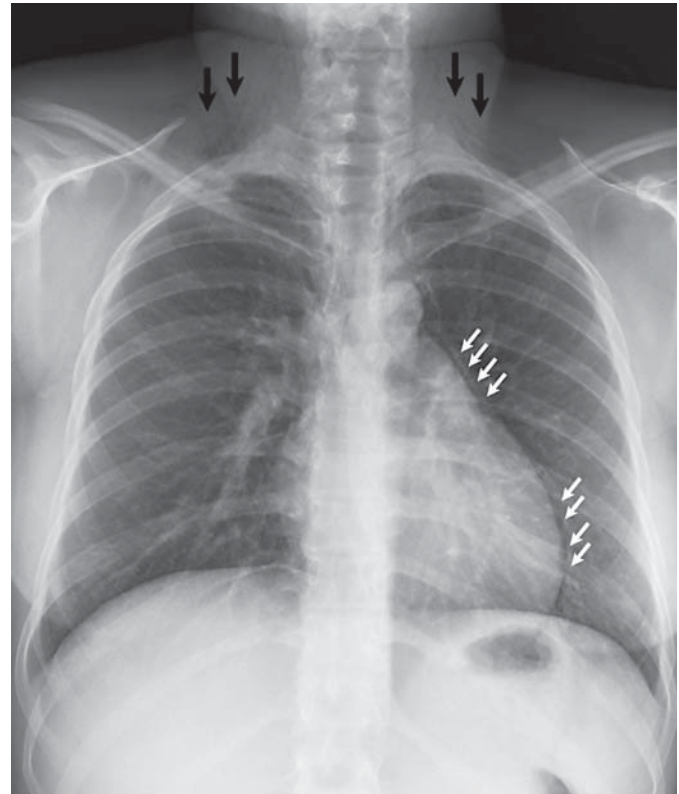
Chest radiograph showing the pneumomediastinum (white arrows) and subcutaneous emphysema (black arrows).
